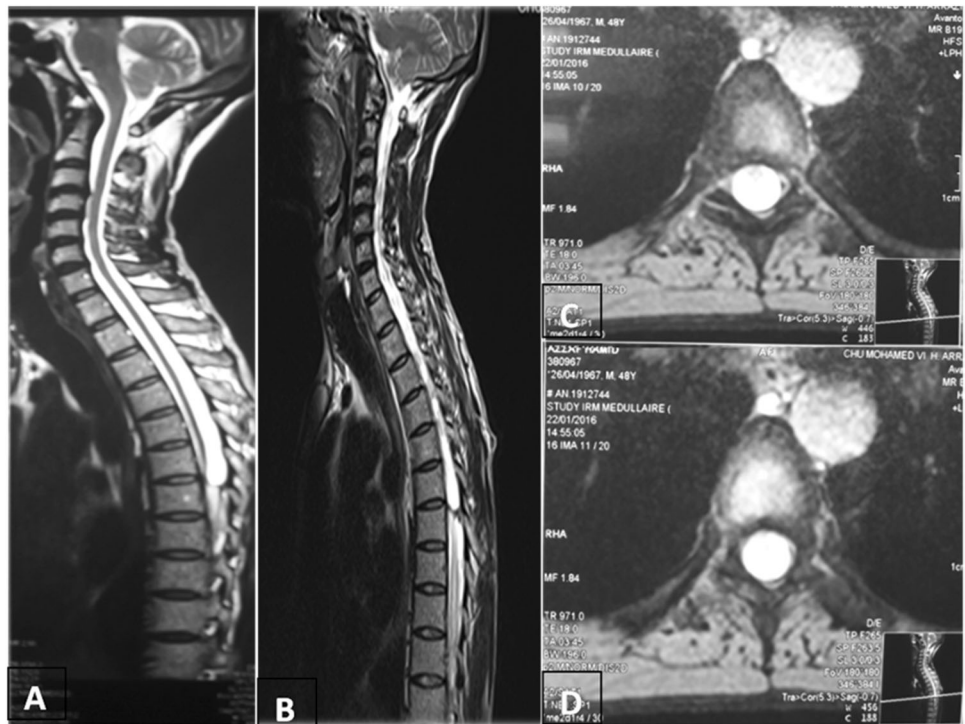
a Sagittal image of the thoracic spinal cord shows hypointense signals on T1 sequence. b Hyperintense signals on T2 in the cord extending from C7 to T4, compatible with syringomyelia. c, d Axial view at the level of T3 shows hyperintense signals on T2 corresponding to a fluid-filled central cavity. e, f Follow-up cervicothoracic spine MRI at 30 months showed that the intramedullary high intensity areas on T2-weighted images disappeared with generalized dorsal cord atrophy
